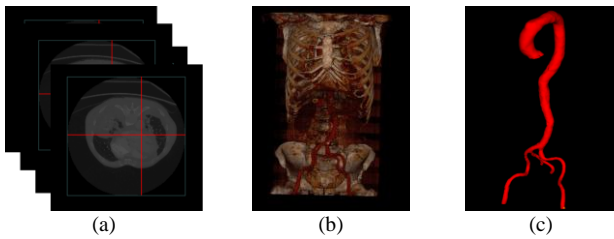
Construct 3D Vascular Model. (a)The preoperative CT scans. (b) The 3D image by volume rendering. (c) The constructed vascular model
